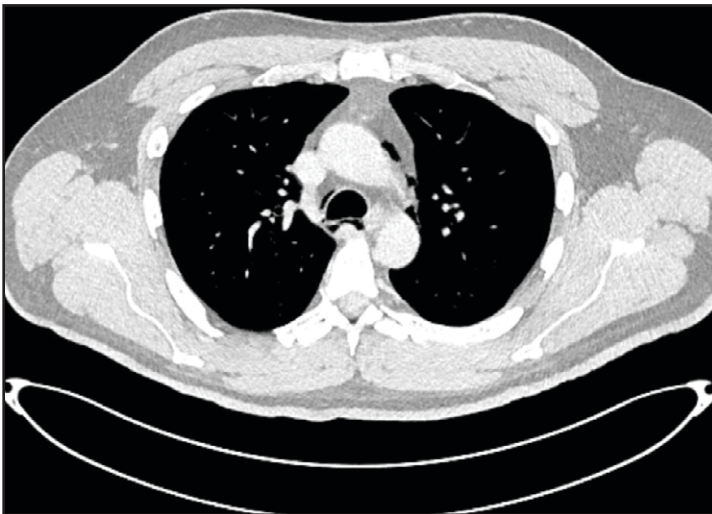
Pneumomediastinum noted on diagnostic chest computed tomography (CT).
